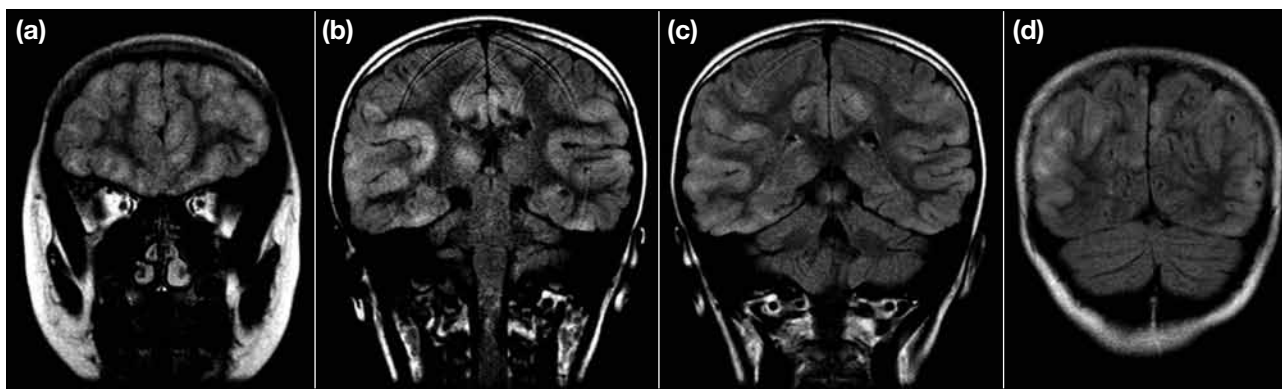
Fluid-attenuated inversion recovery magnetic resonance images showing extensive hyperintense parenchymal lesions at bilateral (a) frontal, (b) temporal, (c) parietal, and (d) occipital lobes, as well as the right thalamus. The lesion extent score was 5.
